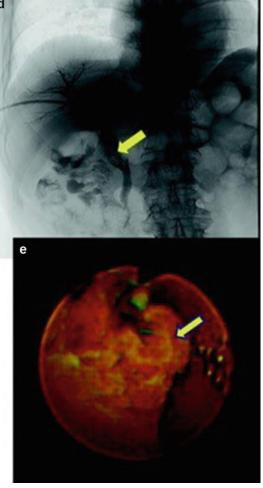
Pretherapeutic extrahepatic bile duct (common bile duct) cancer. [¹⁸F]FDG abnormally accumulates in the common bile duct (a–c; *red arrows*). And fusion image clearly discloses a local relationship between
